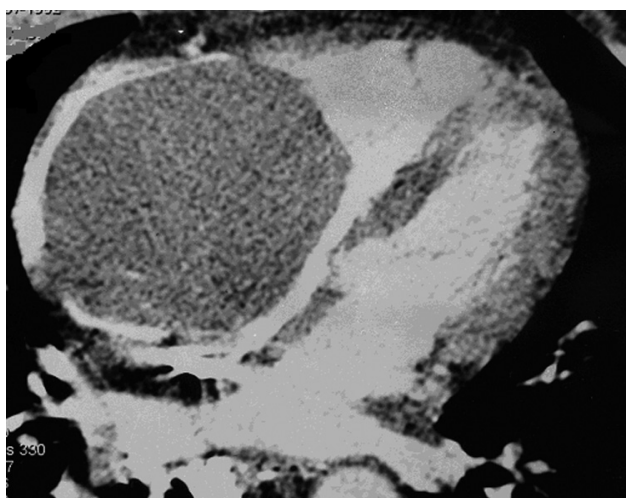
Magnetic resonance image of the giant myxoma, which was filling the entire right atrium.
